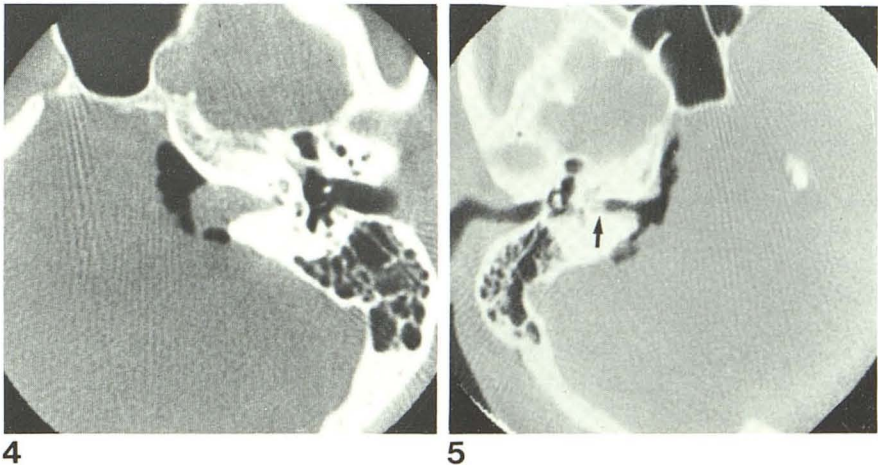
Gas CT cisternography in inflammation of sensory ganglion of cochlear nerve. Gas within right cerebellopontine angle cistern and partially filling internal auditory canal. Soft-tissue density in most lateral aspect of canal prevents complete filling of canal. Border of soft-tissue density is concave to gas. Longitudinal dimension was 3 mm. Although mass lesion was observed and resected at surgery, pathologic examination demonstrated normal sensory ganglion cells with lymphocytic infiltration.
